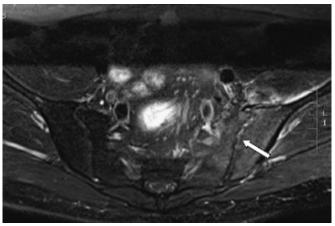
Admission MRI, demonstrating effusion, erosive changes, and bone marrow edema of the left sacroiliac joint, and muscle edema of the left iliacus and gluteus medius.
